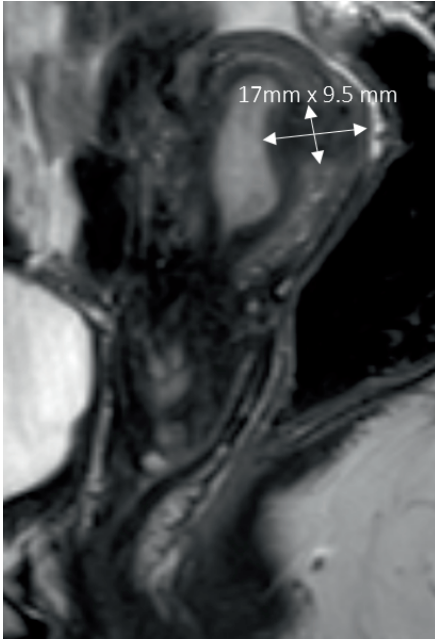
Sagittal T2W MRI showing a focal adenomyosis lesion in the posterior uterine wall
